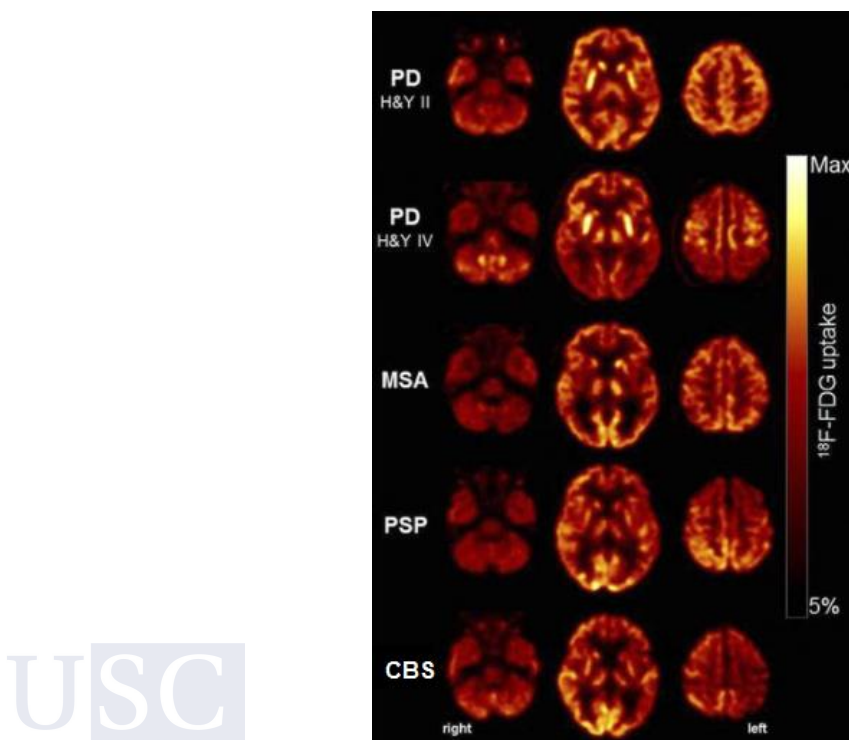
Typical FDG-PET findings in patients with different parkinsonism. Cross-sections at levels of cerebellum, basal ganglia and dorsal frontoparietal cortex in PD (stage 1 and 4), PSP, MSA and CBS. Adapted with permission of JNM from (Meyer et al., 2017).
